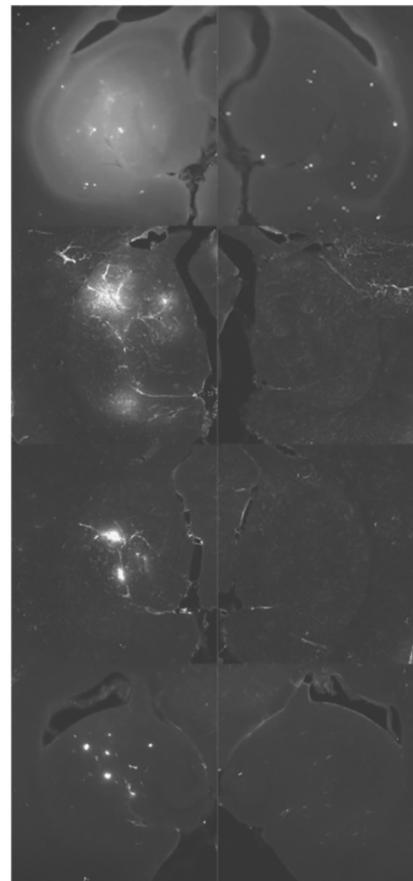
(from Chen and Konofogou, 2014): Brain sections on left were treated with focal ultrasound (FUS) before administration of fluorescently-labeled dextrans and those on the right did not receive FUS.
